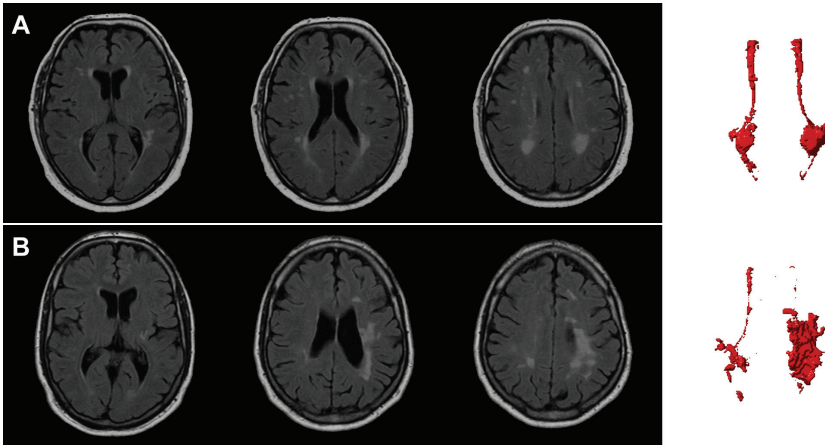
Example of WMH shape difference in two patients (A, B) with comparable WMH volume (11.4 ml vs. 12.2 ml, respectively) but a 2.7 SD difference (Z-scores: 0.10 vs. 2.82, respectively) in concavity index. The three leftmost images in each row are axial FLAIR images at three different levels. The rightmost image is a top-down view of a volumetric rendering of the periventricular/confluent WMH segmentation. Note, the more complex shape of the periventricular/confluent WMH in the patient with the highest concavity index (B).
